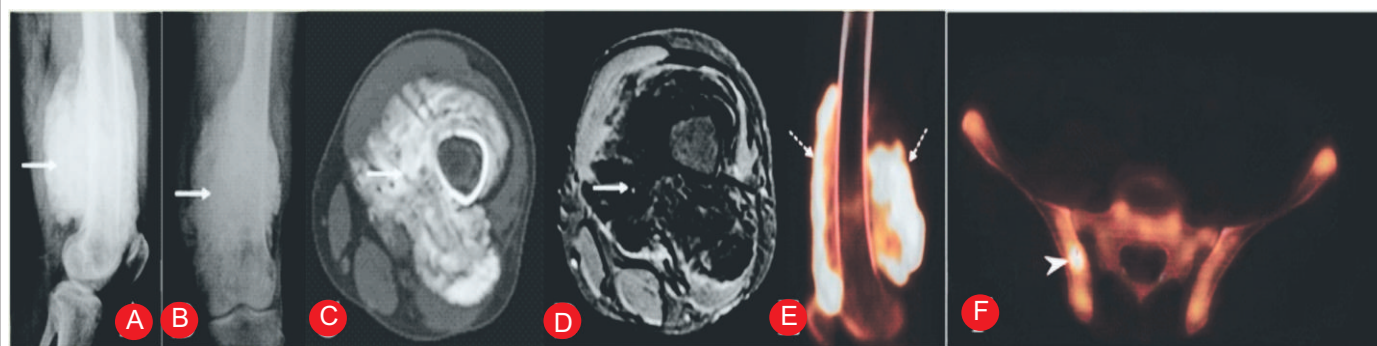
Periosteal osteosarcoma. AP (A) and lateral (B) radiographs show dense ossification surrounding the distal femoral metadiaphysis completely encasing the bone (arrow). Axial CT image (C) and STIR MRI (D) image shows dense osteoid matrix with normal medullary marrow. (E) 18F-FDG-PET/CT shows intense uptake in osteoid matrix (dotted arrow) with proximal sub centimeter sized osteoid lesion in iliac bone (F) turned out to be bone island (arrowhead) on CT guided biopsy.
